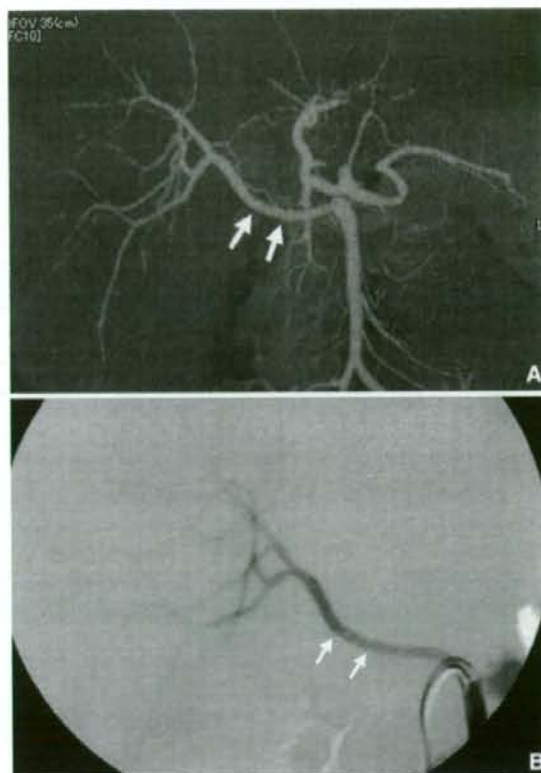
Replaced right hepatic artery in a 46-year-old man with liver metastases. A MSCTA shows the right hepatic artery originating from the superior mesenteric artery (SMA; arrows). B Digital subtraction angiogram (DSA) of the SMA confirms the CT findings
